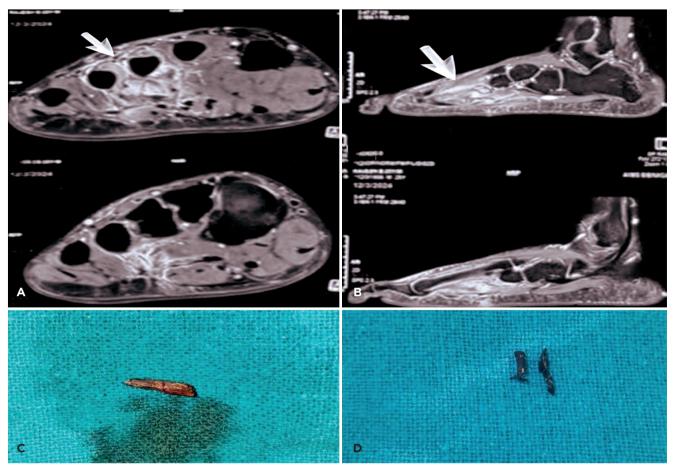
(A) Magnetic resonance imaging T2 short tau inversion-recovery (STIR), axial view. (B) Sagittal images showing extent of collection and tear in muscle fibres of lumbricals and plantar interossei. (C) and (D) Wooden and rubber foreign bodies.
